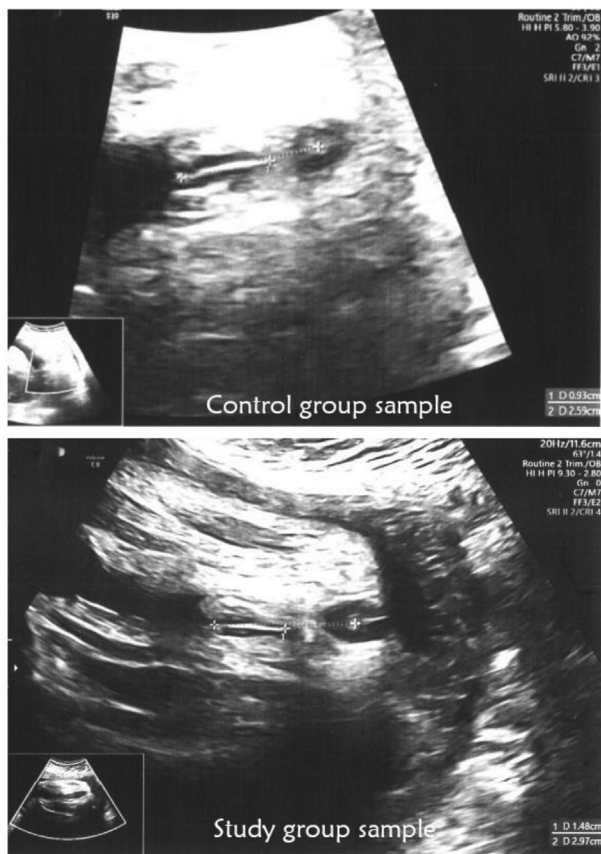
Ultrasound images of AGD measurement from the study group and the control group. In the study group sample, AGD (anus-fourchette distance) is longer and the ratio of anus-fourchette distance/anus-clitoris distance is bigger than in the control group sample.
